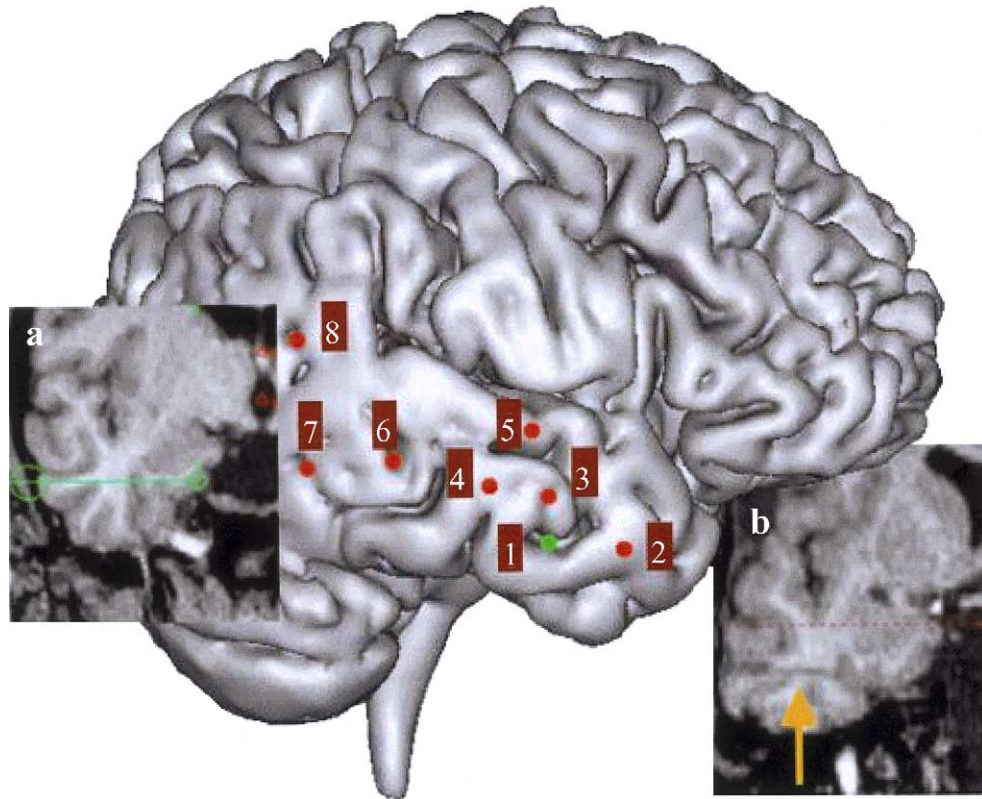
Example of depth electrodes implantation for SEEG in temporal lobe epilepsy. Lateral view of all depth electrodes (patient GAR) superimposed on a 3D image. (a) and (b): coronal view of a pre-operative plan (a) and post-implantation (b) MRI of depth electrode route superimposed on a T1 MRI image. The selected slice shows the position of the electrode #1 (in green) reaching the collateral sulcus region at the end (in b, the arrow indicates the route of this electrode). Electrode #1 records the electrophysiological activity (EA) within the entorhinal cortex (internal contacts) and the anterior part of the inferior temporal gyrus (external contacts); electrode #2 records EA within the temporal pole (internal and external contacts), electrode #3 records the EA in the amygdala (internal contacts) and within the anterior part of the middle temporal gyrus (external contacts); electrode #4 records the EA within the hippocampal head (internal contacts) and the middle part of the middle temporal gyrus (external contacts), electrode #5 records EA within the anterior part of the insula (internal contacts) and the anterior part of the superior temporal gyrus (external contact); electrode #6 records EA within the hippocampal tail (internal contact) and the posterior part of the middle temporal gyrus (external contacts); electrode #7 records EA within the occipito-temporal junction and electrode #8 records EA within the isthmus of the cingulate gyrus (internal contacts) and the supra-marginalis gyrus (external contact).
